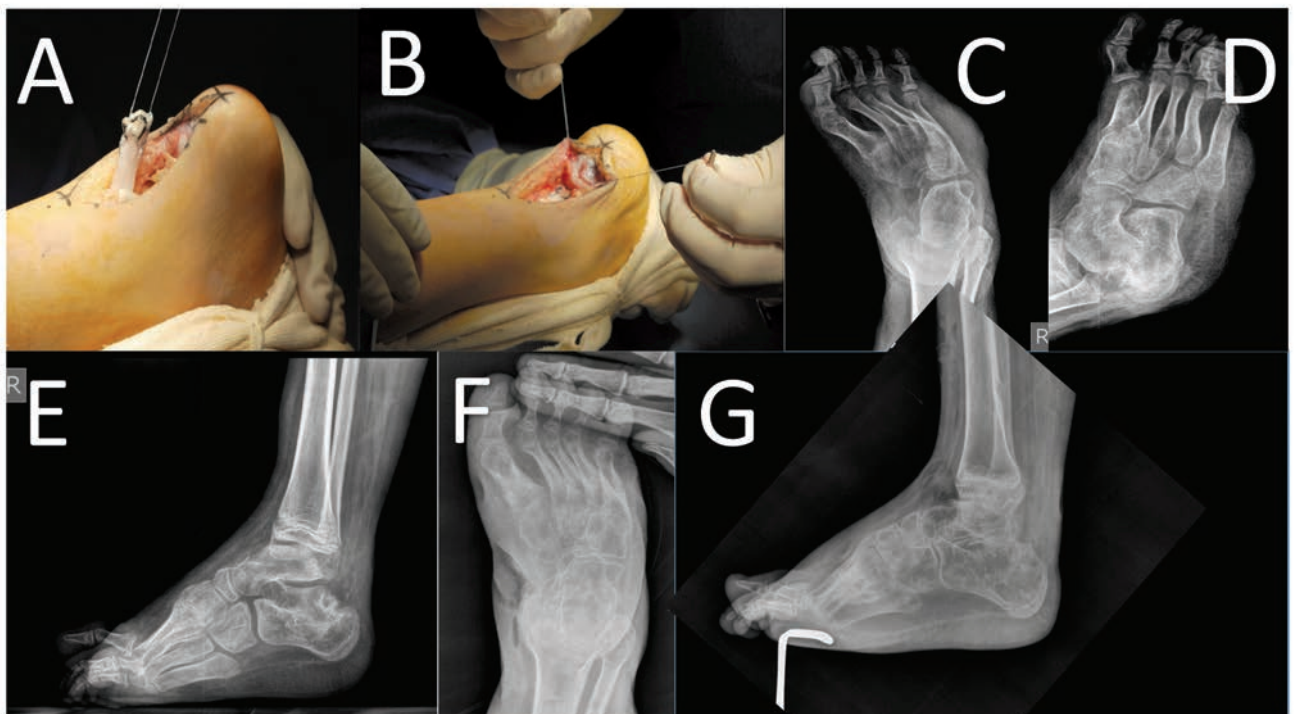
(A-B) Intra-operative images of Pierrot-Murphy procedure. (C-E) Pre-operative radiographs demonstrating radiographic characteristics of Talipes Equinovarus deformity and relative absence of degenerative changes. (F-G) Post external fixation removal showing satisfactory reduction of equinovarus deformity.
